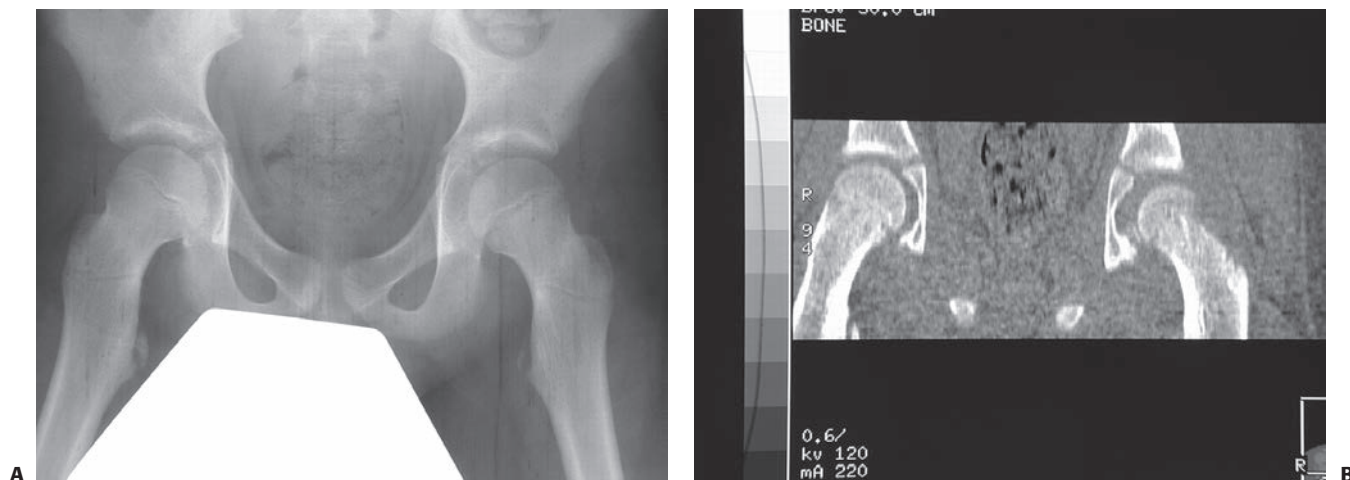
Spontaneously reduced left hip but with persistent pain. The joint space on the left is widened (A). The CT scan shows interposed soft tissue in the left hip (B).
